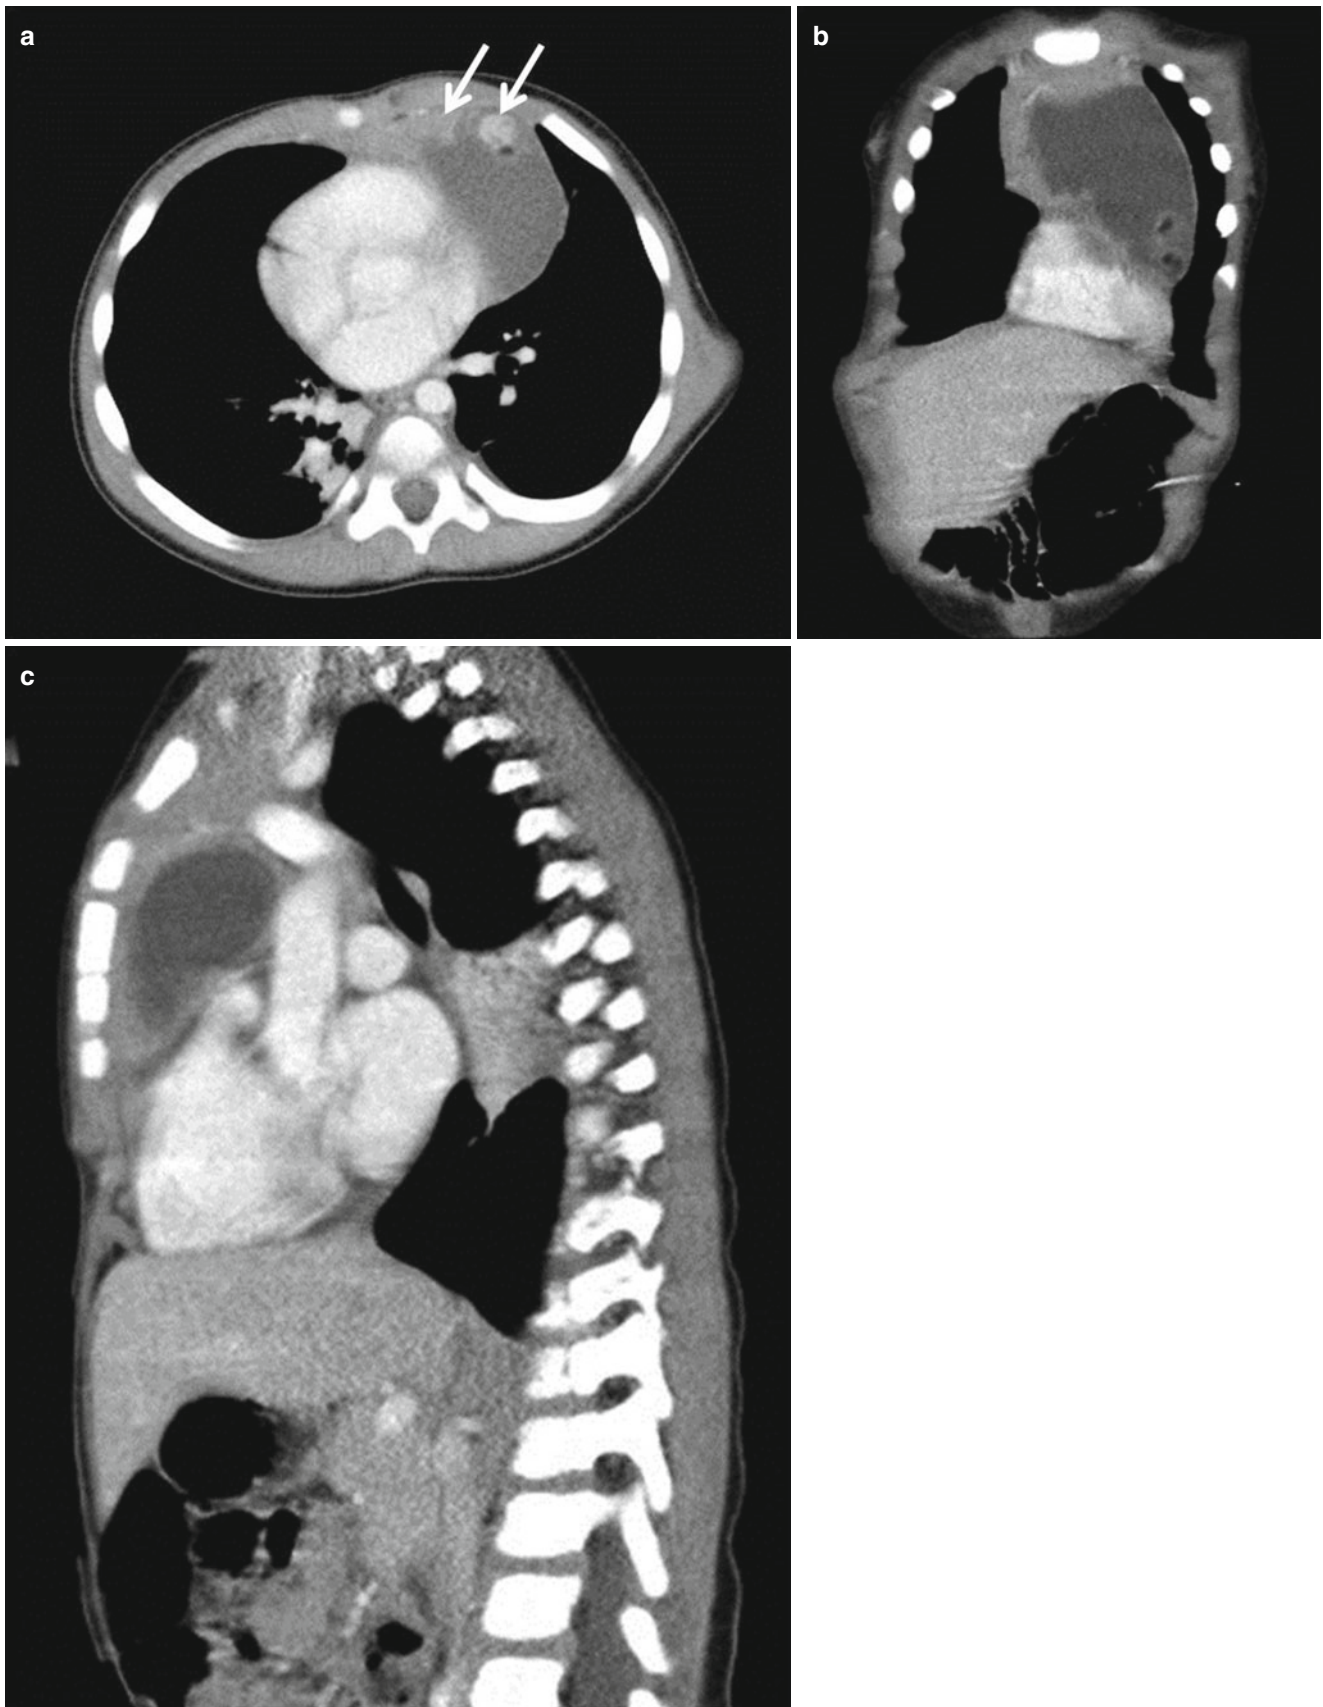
(a) Axial, (b) coronal, and (c) sagittal CT scan of a 22 month old boy presenting with fever, cough, and weight loss. The anterior mediastinal mass is predominately cystic, with small solid components containing calcifications and fat densities (*white arrows*), arising from
